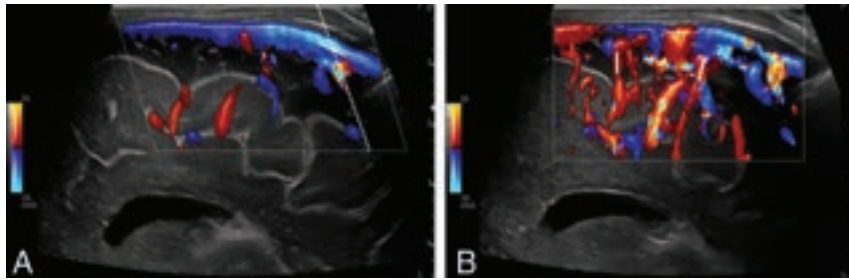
Doppler imaging protocol of the SSS and cortical veins in a median sagittal section. A, SSS in median sagittal section in color-coded Doppler US with tilted Doppler beam (*dotted line*) and corresponding angular correction (*white line*). B, Cortical arteries and veins in sagittal section in color-coded Doppler US show possible measurement points (*white lines*).
